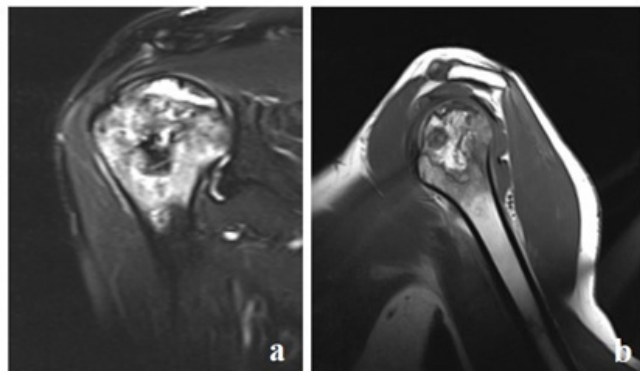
MR images in different planes and modalities showing Stage-2 osteonecrosis in both shoulder joints.
